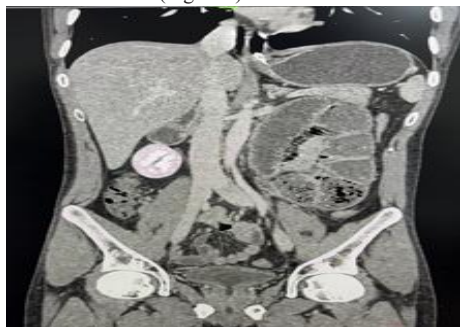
Coronal contrast-enhanced CT image showing an encapsulated cluster of dilated small bowel loops in the left hypochondrium/lumbar region, with crowding of mesenteric vessels.
